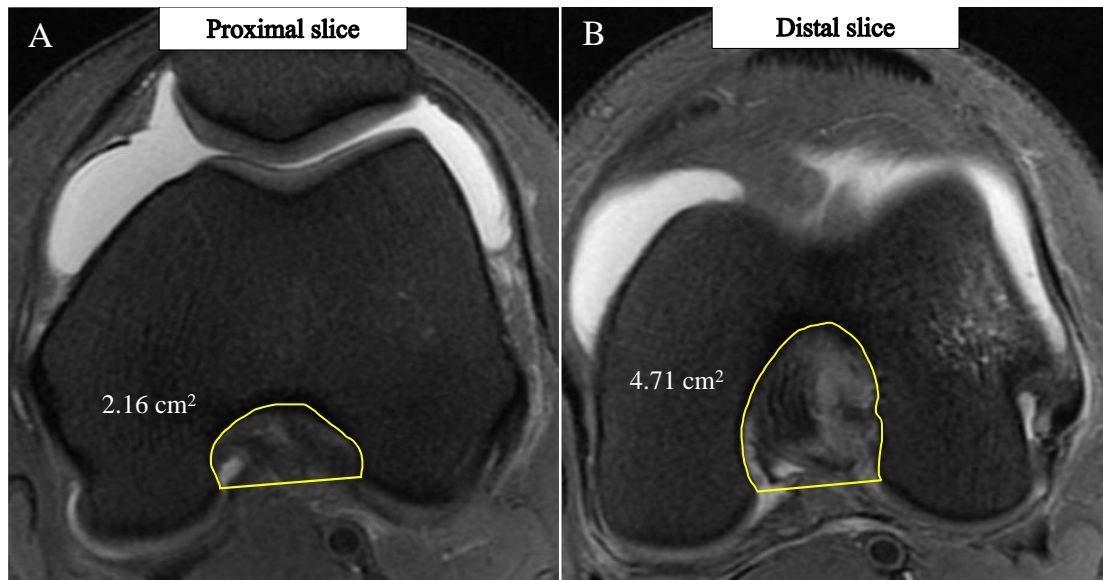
Notch volume measurement in subsequent axial cuts on MRI
